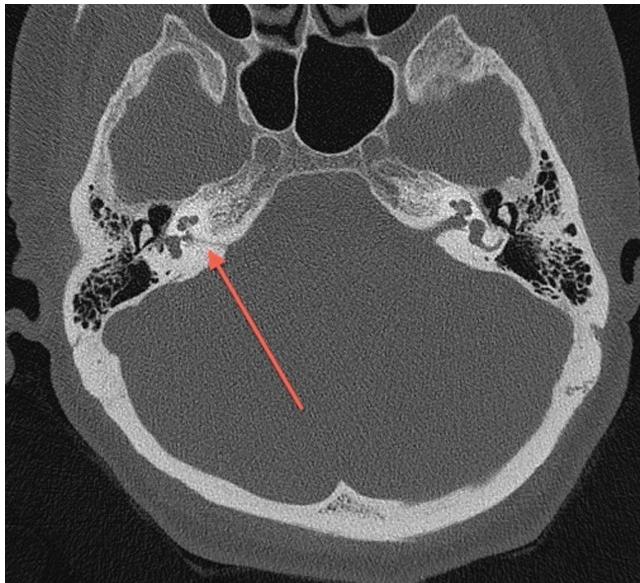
CT-HRCT scan no. 618/11/CT1: pathological presentation of the internal auditory canal on the right. A narrow, bipartite canal, with the first canal, 1.8–2.3 mm in diameter, being located along the course of the anterosuperior part of properly developed canal, and the second, fissure-like canal, 0.5 mm in diameter, being located somewhat inferior and posterior to the first canal; both canals merge medially away from the vestibule. Also visible is the canal of the inferior vestibular nerve which innervates the saccular macula and the posterior ampillary crest; left temporal bone presentation unremarkable.
